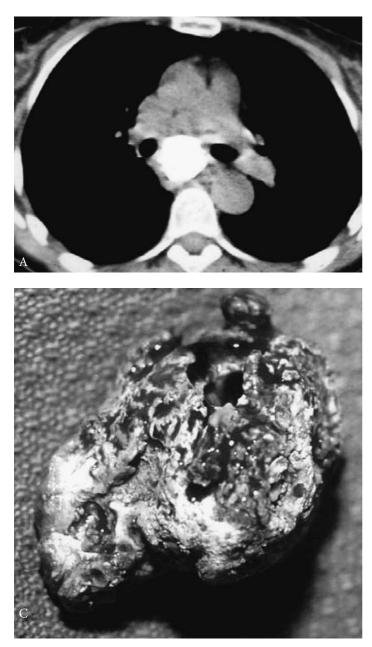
Mass of calcified subcarinal lymph nodes due to histoplasmosis, with broncholithiasis of the left main bronchus. A, Computed tomography scan showing a calcified mass. B, Tomogram of the carina in the same patient. The arrow points to the broncholith protruding into the bronchial lumen. C, The mass excised with an attached intrabronchial extension. The bronchus was closed longitudinally in this particular patient, which is not always possible. Also, see Figure 36 (Color Plate 16).
